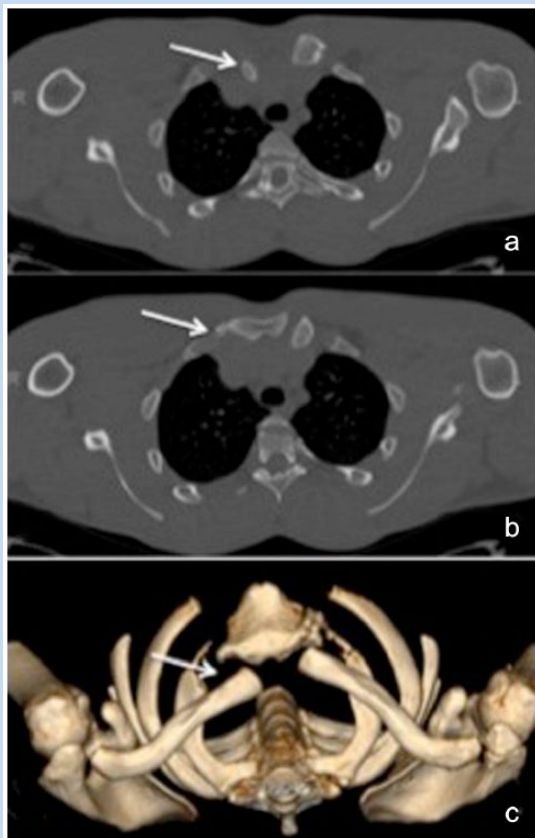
Postinjury axial CT images. (a) Axial cut depicting the posteriorly displaced right medial clavicle (white arrow). (b) Right sternoclavicular dislocation as evidenced by absence of the right medial clavicle at the level of the sternoclavicular joint (white arrow). (c) Three-dimensional reconstruction clearly demonstrating the right posterior sternoclavicular joint dislocation (white arrow).
